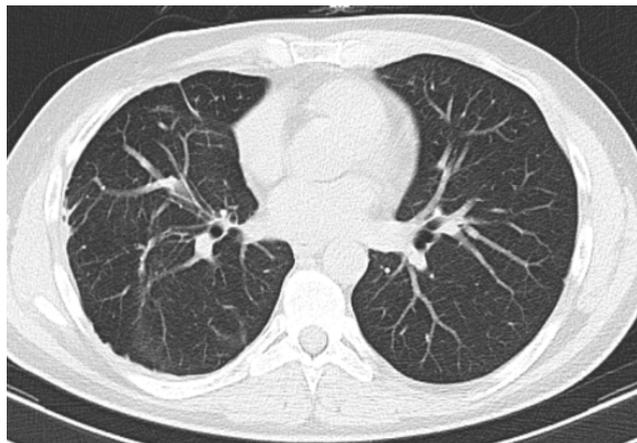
Chest CT of October 18, 2016. Positive changes on chemotherapy. Fibrosing changes in both lungs
